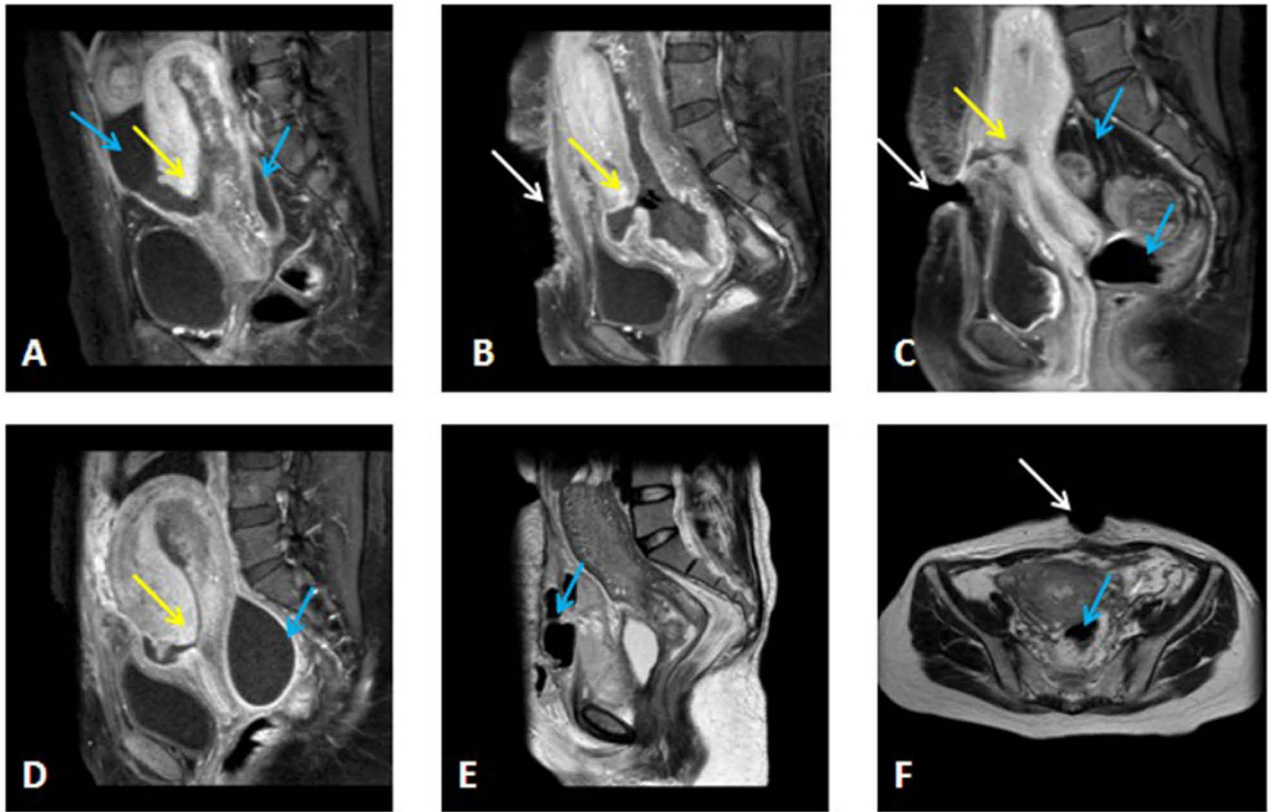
Sagittal T1-weighted image contrast (A–D) obtained after CS demonstrates a mixed signal intensity mass located (blue arrows) in the pelvis. There were uterine dehiscences (yellow arrows) and wound dehiscences (white arrows). Sagittal T2-weighted image (E) and coronal T2-weighted image (F) demonstrate pelvic abscess (blue arrows) and wound dehiscences (white arrows).
